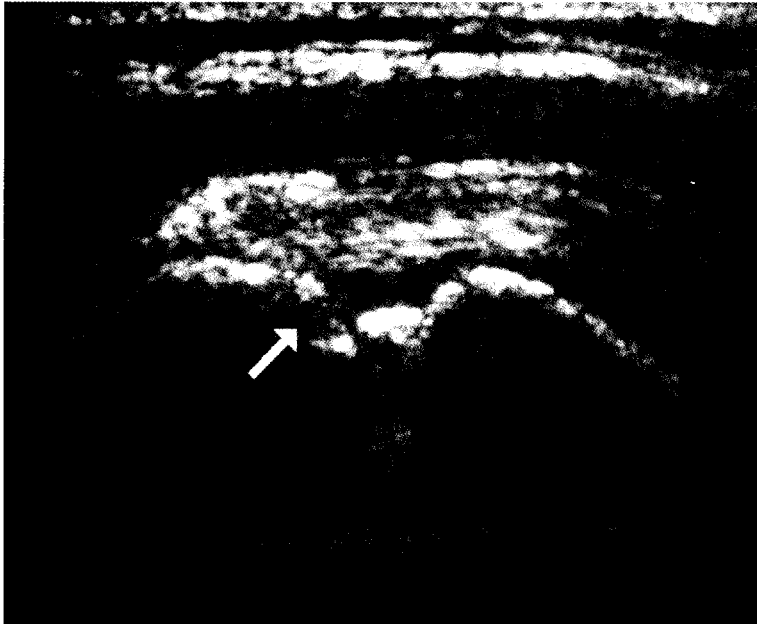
Ultrasound demonstrating supraspinatus muscle tear.
